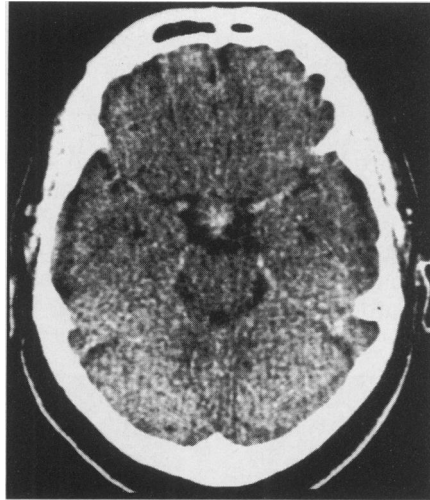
Axial CT scan of brain
